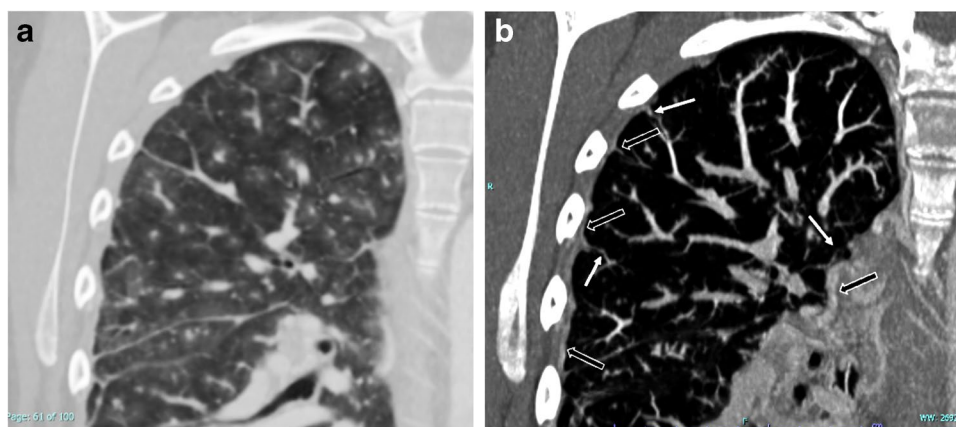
Pulmonary hypertension in girl with *BMRP2* mutation (Patient 3). a Axial CT angiogram of the chest at age 12 demonstrates multiple ground-glass nodules throughout the chest with prominent central vessels. b Axial non-contrast CT in the same girl at age 14 years, about 2 years after she received a Potts shunt (left pulmonary artery to descending aorta, not shown), demonstrates decreased prominence
